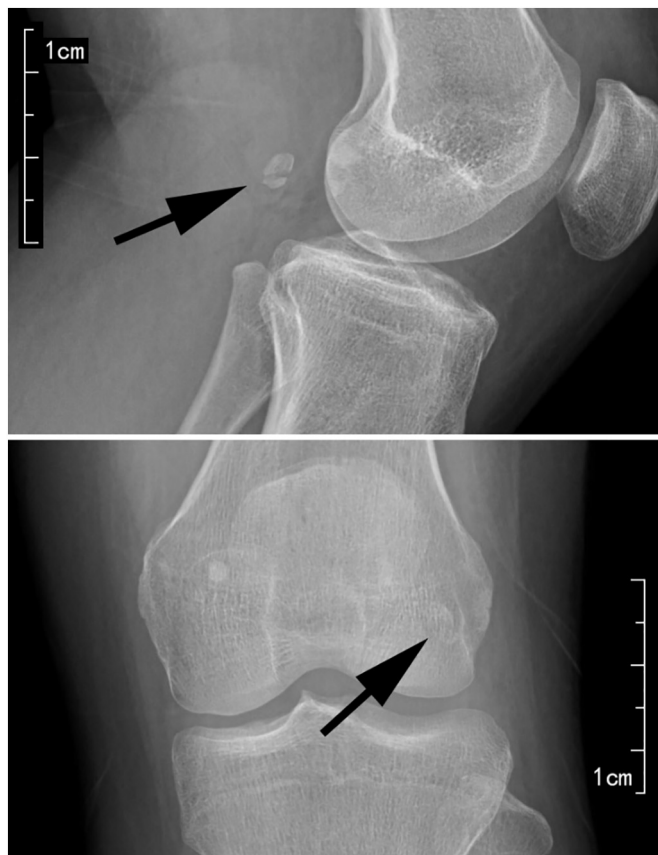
Lateral and anteroposterior X-ray plain film of the left knee revealed a transverse radiolucent line across the fabella (black arrow).
